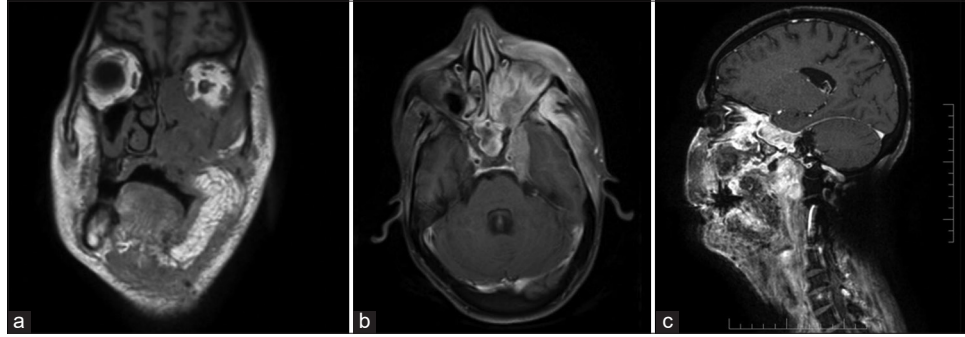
(a) CE-MRI NECK – An ill-defined T2/STIR high signal intensity lesion noted involving the flap region showing no significant restriction of diffusion and no blooming in gradient sequences. (b) CE-MRI NECK – An ill-defined high signal intensity lesion appears to extend into the left orbital apex and left cavernous sinus with left intraconal extension. (c) CE-MRI NECK – Ill-defined high signal intensity lesion appears to encase the optic nerve within the optic canal and intraconal region.
